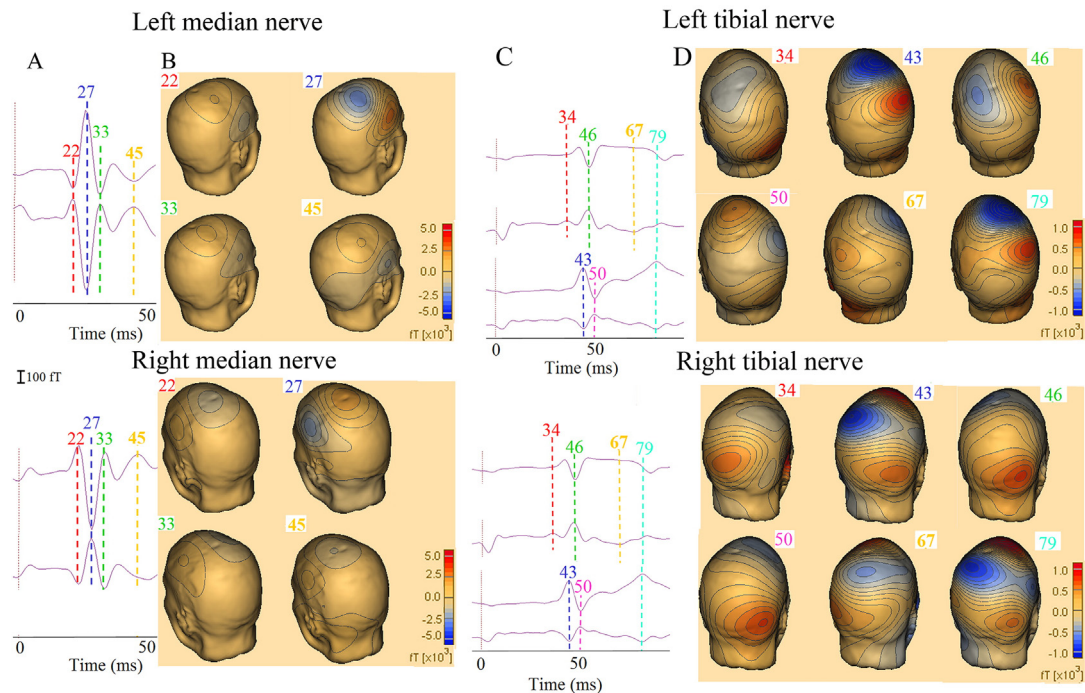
Median and tibial nerve SEFs a) Mean SEFs from two magnetic channels following the left and right median nerve stimulation showing four components: N22m-P22m (red line), N27m-P27m (blue line), N33m-P33m (green line), and N45m-P45m (yellow line). b) MEG field topography on patient structural MRI at 22 ms, 27 ms, 33 ms and 45 ms. c) Mean SEFs from four magnetic channels following the left and right tibial nerve stimulation showing six components: N34m-P34m (red line), N43m-P43m (blue line), N46m-P46m (green line), N50m-P50m (pink line), N67m-P67m (yellow line), N79m-P79m (cyan line). d) MEG field topography on patient structural MRI at 34 ms, 43 ms, 46 ms, 50 ms, 67 ms and 79 ms. (For interpretation of the references to color in this figure legend, the reader is referred to the web version of this article.)
